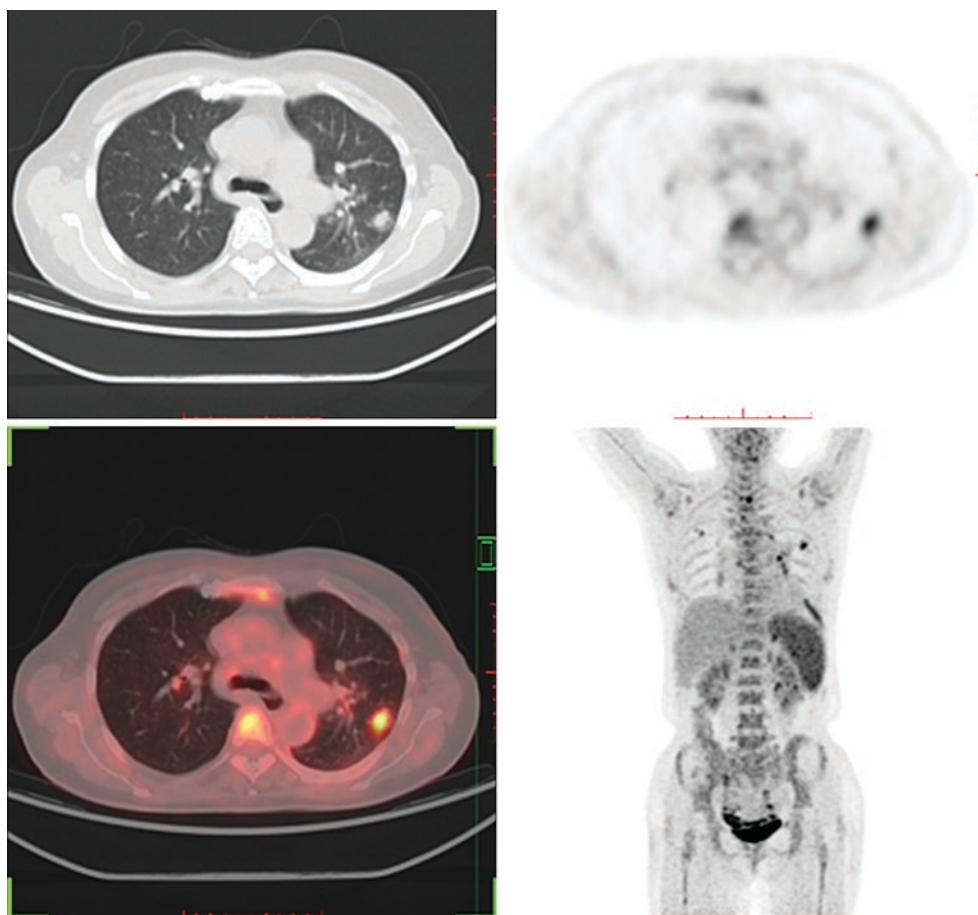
Multiple pulmonary lesions with avid FDG uptake implied infection on lung window CT image and MIP image. MIP map shows enlarged spleen with diffuse high FDG uptake ($SUV_{max} = 4.9$)
